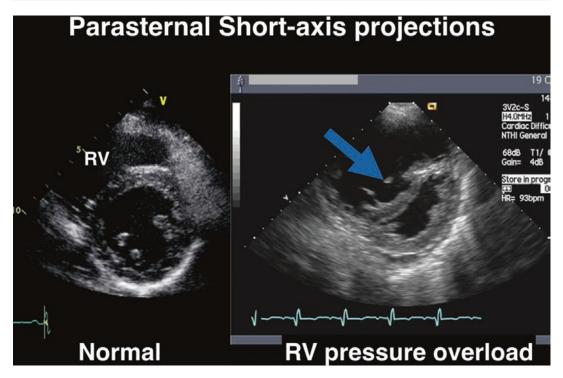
Parasternal short-axis view demonstrating a perfect circular expansion in systole from a normal individual (left) but in a patient with markedly elevated RV
